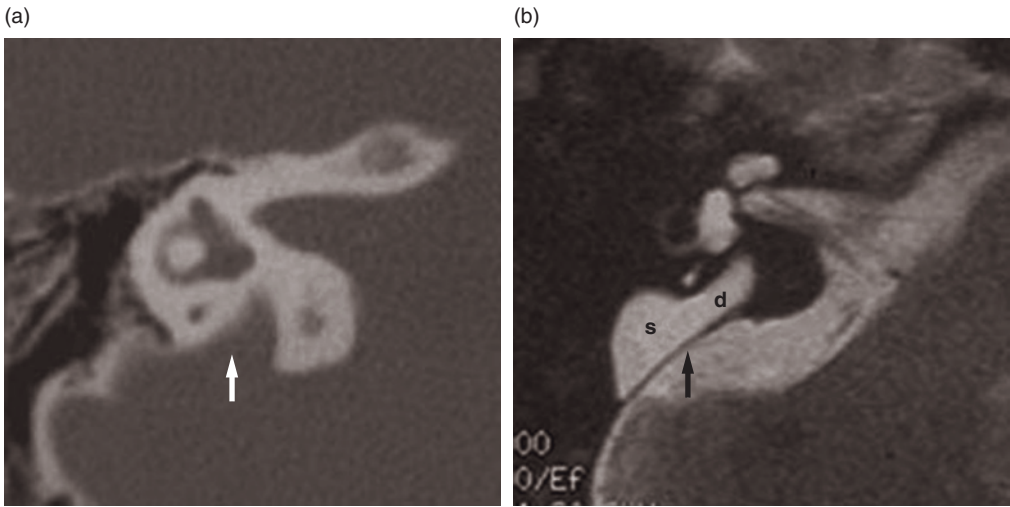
Axial CT (a) and T2-weighted MR (b) images. CT shows dilation of the vestibular aqueduct (white arrow), while enlargement of the endolymphatic duct (d) and sac (s) is demonstrated by MR. The dura (black arrow) separates the sac and subarachnoid spaces. Patient with Pendred syndrome.
